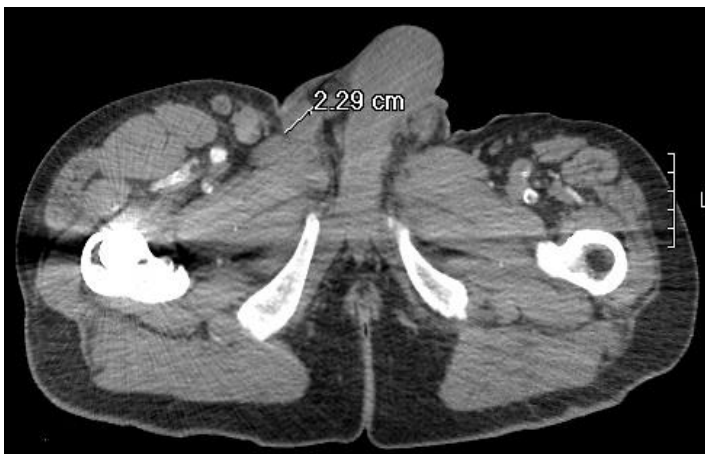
CT Pelvis with prominent lymph node in the right scrotum measuring 2.29 cm
